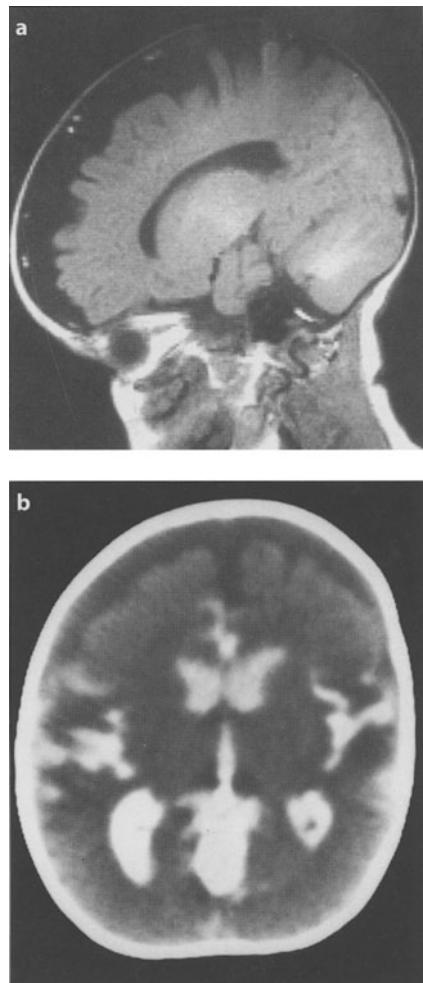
A 5-month-old patient with achondroplasia and "external hydrocephalus." a Parasagittal T1-weighted MRI shows a pericerebral effusion with apparent dilated "subarachnoid" spaces. b Axial CT scan after contrast injection in the lumbar subarachnoid spaces: the ventricles are opacified, as are the sylvian fissures, but not the anterior dilated "subarachnoid" spaces
